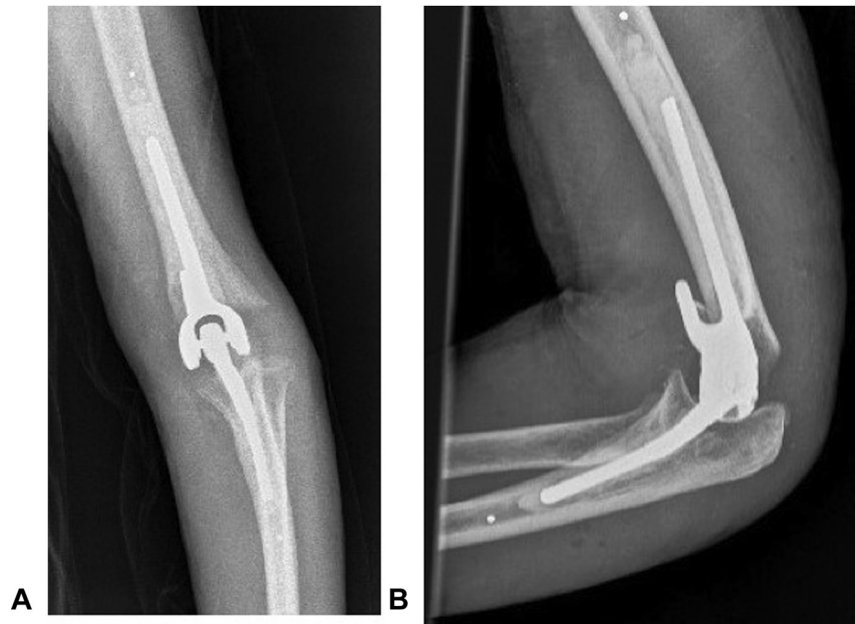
Immediate postoperative imaging: A posteroanterior and B lateral radiograph of TEA.
